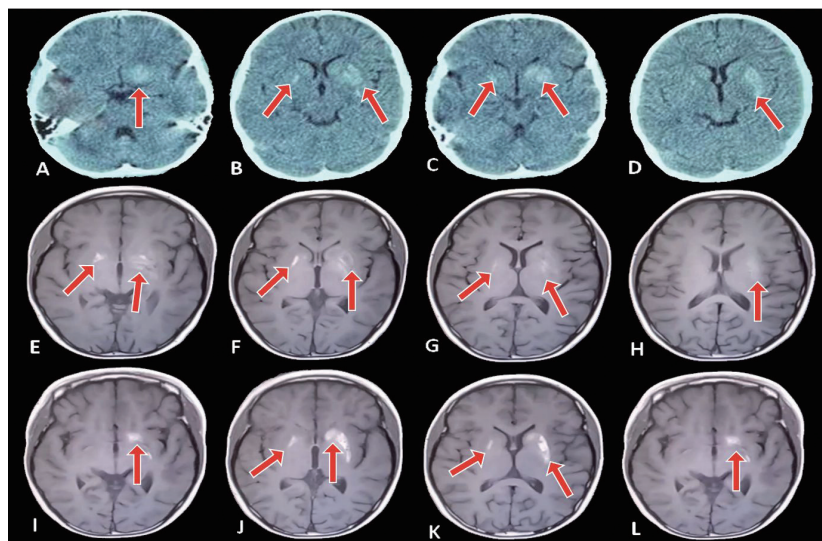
Cranial computed tomography scan that showed asymmetric hyperdensity of both corpus striatum, more prominently involving the left (red arrow) (A-D). Cranial MRI showing abnormal signals in both basal ganglia, more on the left (red arrows) (E-H). Repeat Cranial MRI two months post-discharge showed increase abnormal signals in both basal ganglia (red arrow) (I-L).
